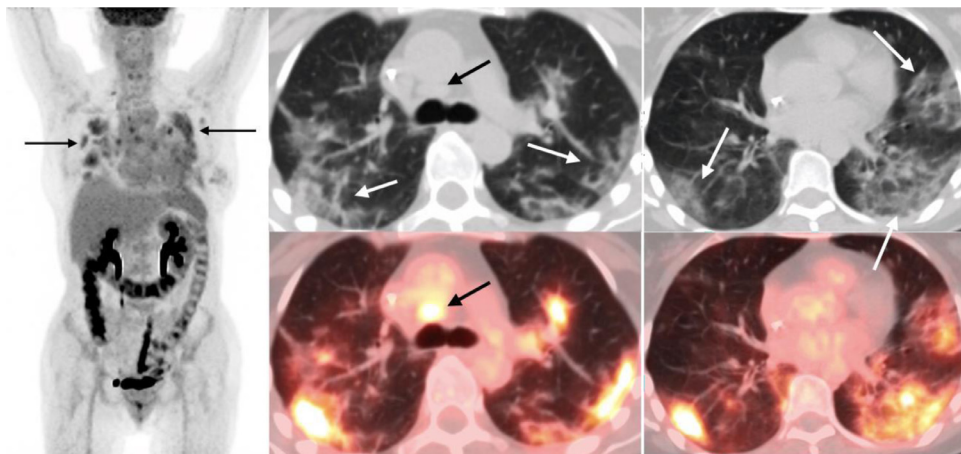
54-year-old female with breast cancer on chemotherapy presents for restaging PET/CT. MIP images demonstrate hypermetabolic foci in the lungs and mediastinum (black arrows). Axial PET/CT shows bilateral confluent ground-glass opacities (white arrows) and precarinal lymph node (black arrow).
